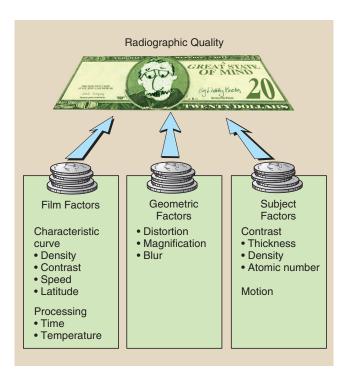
Organization chart of principal factors that may affect radiographic quality.
